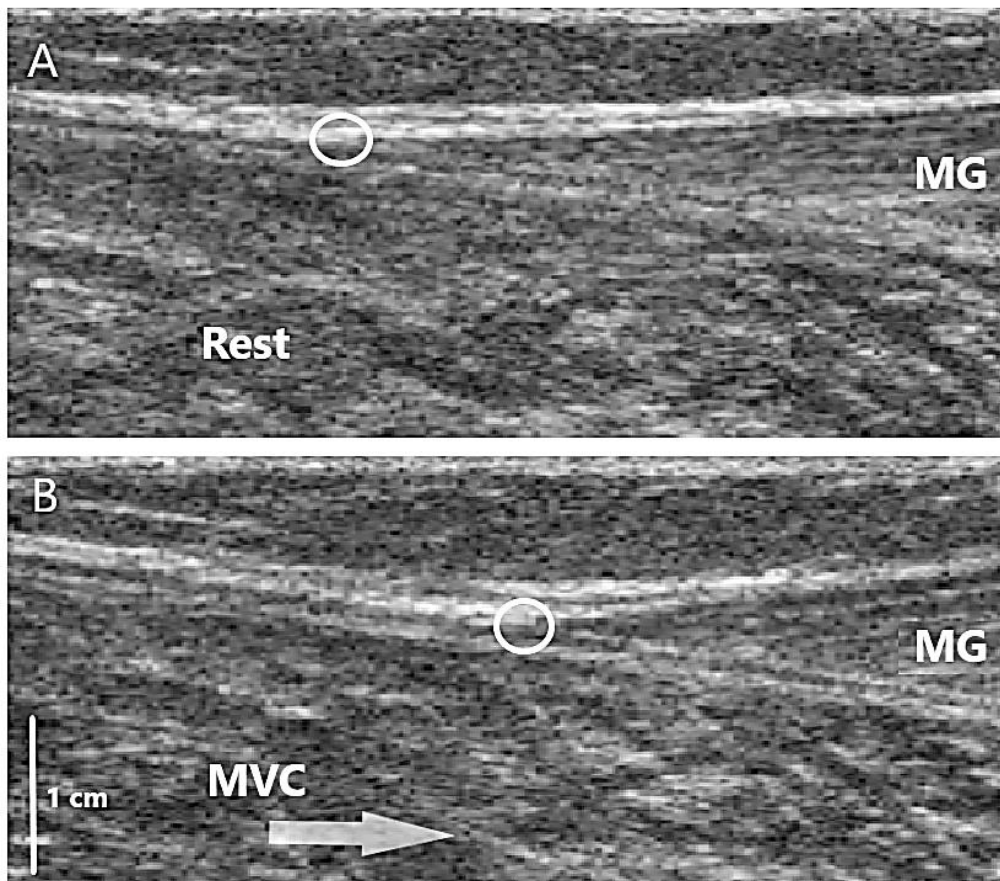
B-mode ultrasound images of the MG MTJ (A) at rest and (B) during MVC. Circles indicate the position of the tracked MTJ.
